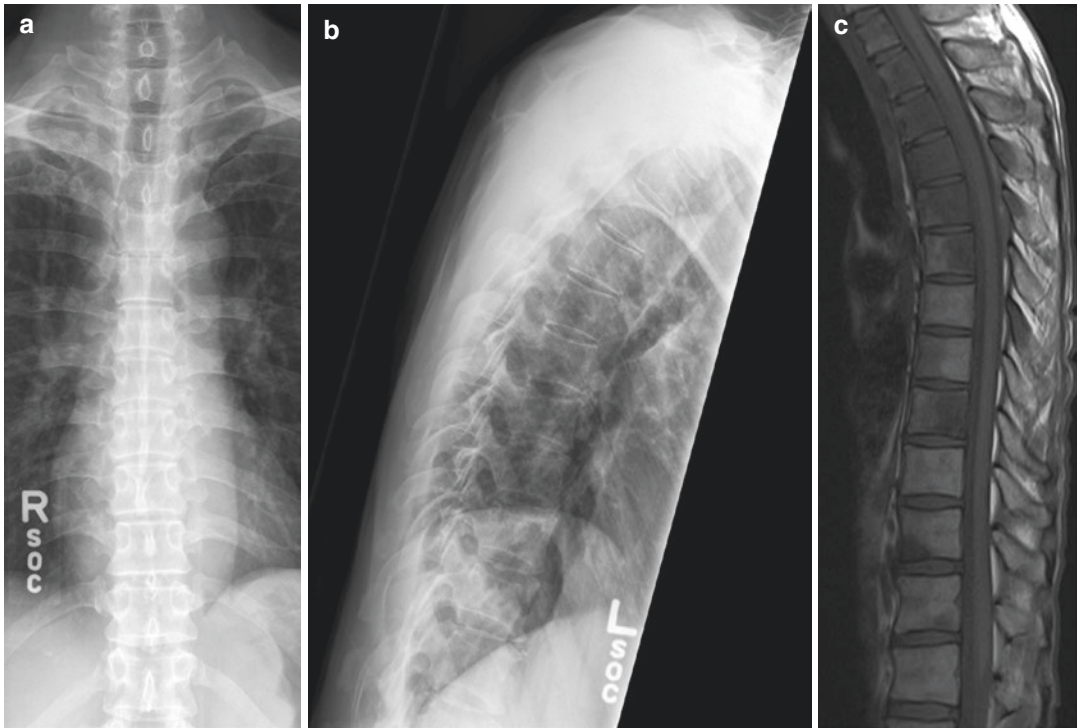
A 51-year-old man who presented with back pain of insidious onset. (a) Frontal and (b) lateral radiographs of the thoracic spine appear essentially normal. There is no radiographic evidence of osseous metastasis. (c) Sagittal T1-W MR image of the thoracic spine shows
